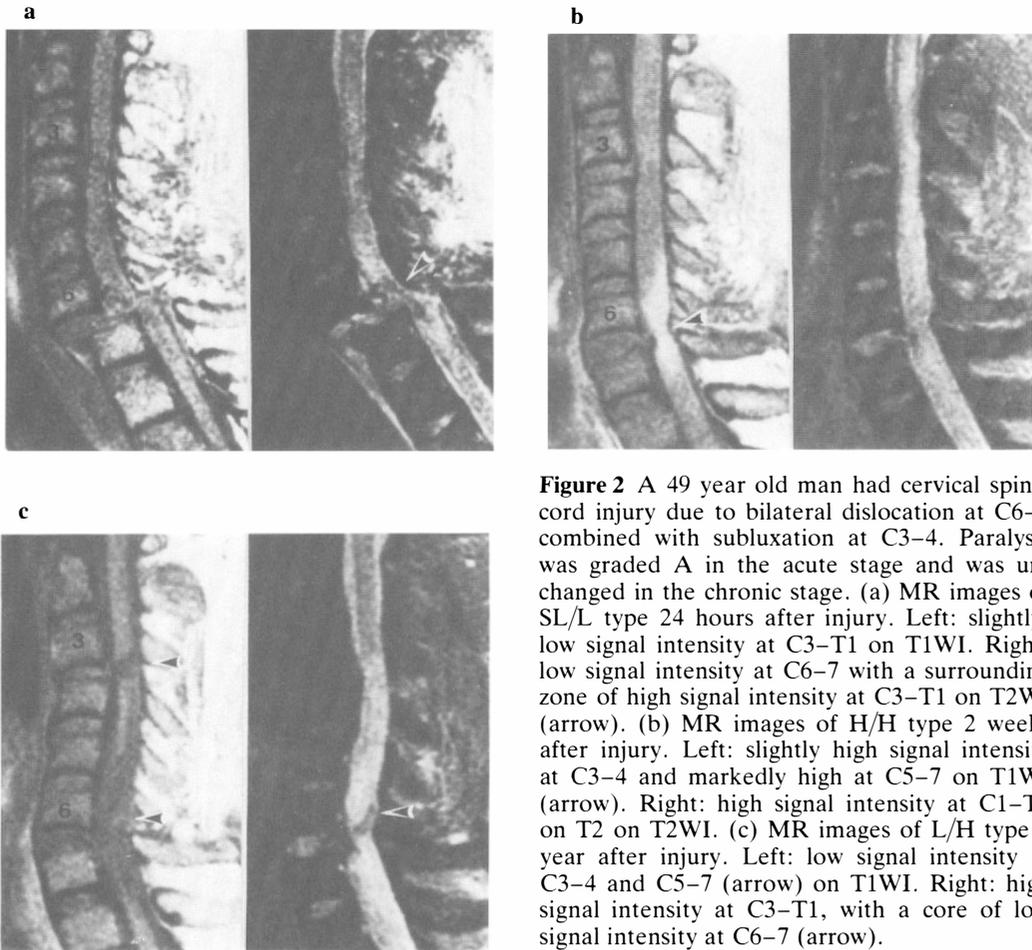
A 49 year old man had cervical spinal cord injury due to bilateral dislocation at C6-7 combined with subluxation at C3-4. Paralysis was graded A in the acute stage and was unchanged in the chronic stage. (a) MR images of SL/L type 24 hours after injury. Left: slightly-low signal intensity at C3-T1 on T1WI. Right: low signal intensity at C6-7 with a surrounding zone of high signal intensity at C3-T1 on T2WI (arrow). (b) MR images of H/H type 2 weeks after injury. Left: slightly high signal intensity at C3-4 and markedly high at C5-7 on T1WI (arrow). Right: high signal intensity at C1-T2 on T2 on T2WI. (c) MR images of L/H type 1 year after injury. Left: low signal intensity at C3-4 and C5-7 (arrow) on T1WI. Right: high signal intensity at C3-T1, with a core of low signal intensity at C6-7 (arrow).
